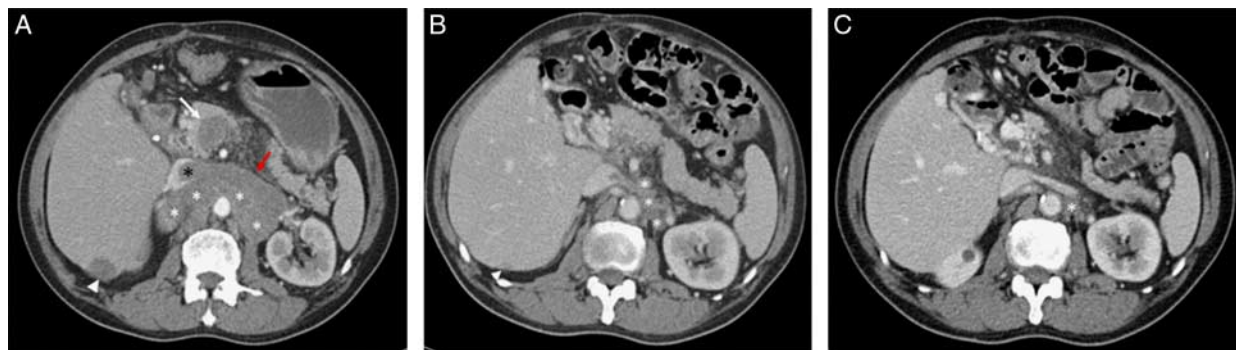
Case 1 computed tomography (CT) scans over treatment course. A, CT axial image with intravenous contrast performed 14 months after initial diagnosis and 4 days before dual immunotherapy implementation demonstrates right lobe metastasis (white arrowhead) and retroperitoneal lymphadenopathy (white *) with left renal vein tumor thrombus (red arrow) extending to IVC (black *) and portal vein tumor thrombus (white arrow) extending from peripancreatic lymphadenopathy not included in the image. B, Axial image of CT abdomen performed 19 months after initial staging, and 5 months after dual immunotherapy demonstrates significant interval decrease in size of right posterior liver metastasis (white arrowhead), retroperitoneal lymphadenopathy (white *) and complete resolution of left renal vein and portal vein tumor thrombus with trace residual fibrotic tissue. C, Axial CT abdomen 33 months after initial staging, 19 months after initiation of dual immunotherapy, and 9 months after SBRT to retroperitoneal lymphadenopathy demonstrate further decrease in retroperitoneal lymphadenopathy size (white *), and complete resolution of renal vein and portal vein thrombus. Right hepatic lobe metastasis remained significantly smaller since initiation of dual immunotherapy, and morphologically consistent with posttreatment change (not included in the imaging field). full color online
